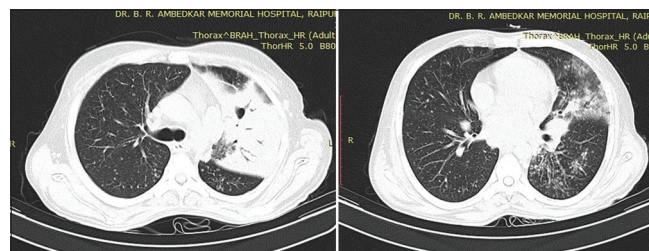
HRCT axial images showing airspace consolidation, focal bronchiectasis, and micronodules in a case of bacterial pneumonia (culture positive for streptococcus)
